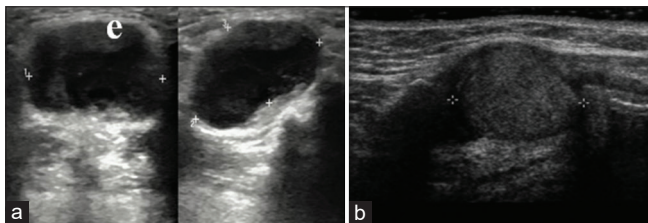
(a and b) Ultrasonography neck revealed a well-defined lobulated anechoic lesion noted just below the hyoid bone and overlying the surface of right thyroid cartilage in the right paramedian region measures 50.88x21.21x19.86 mm
